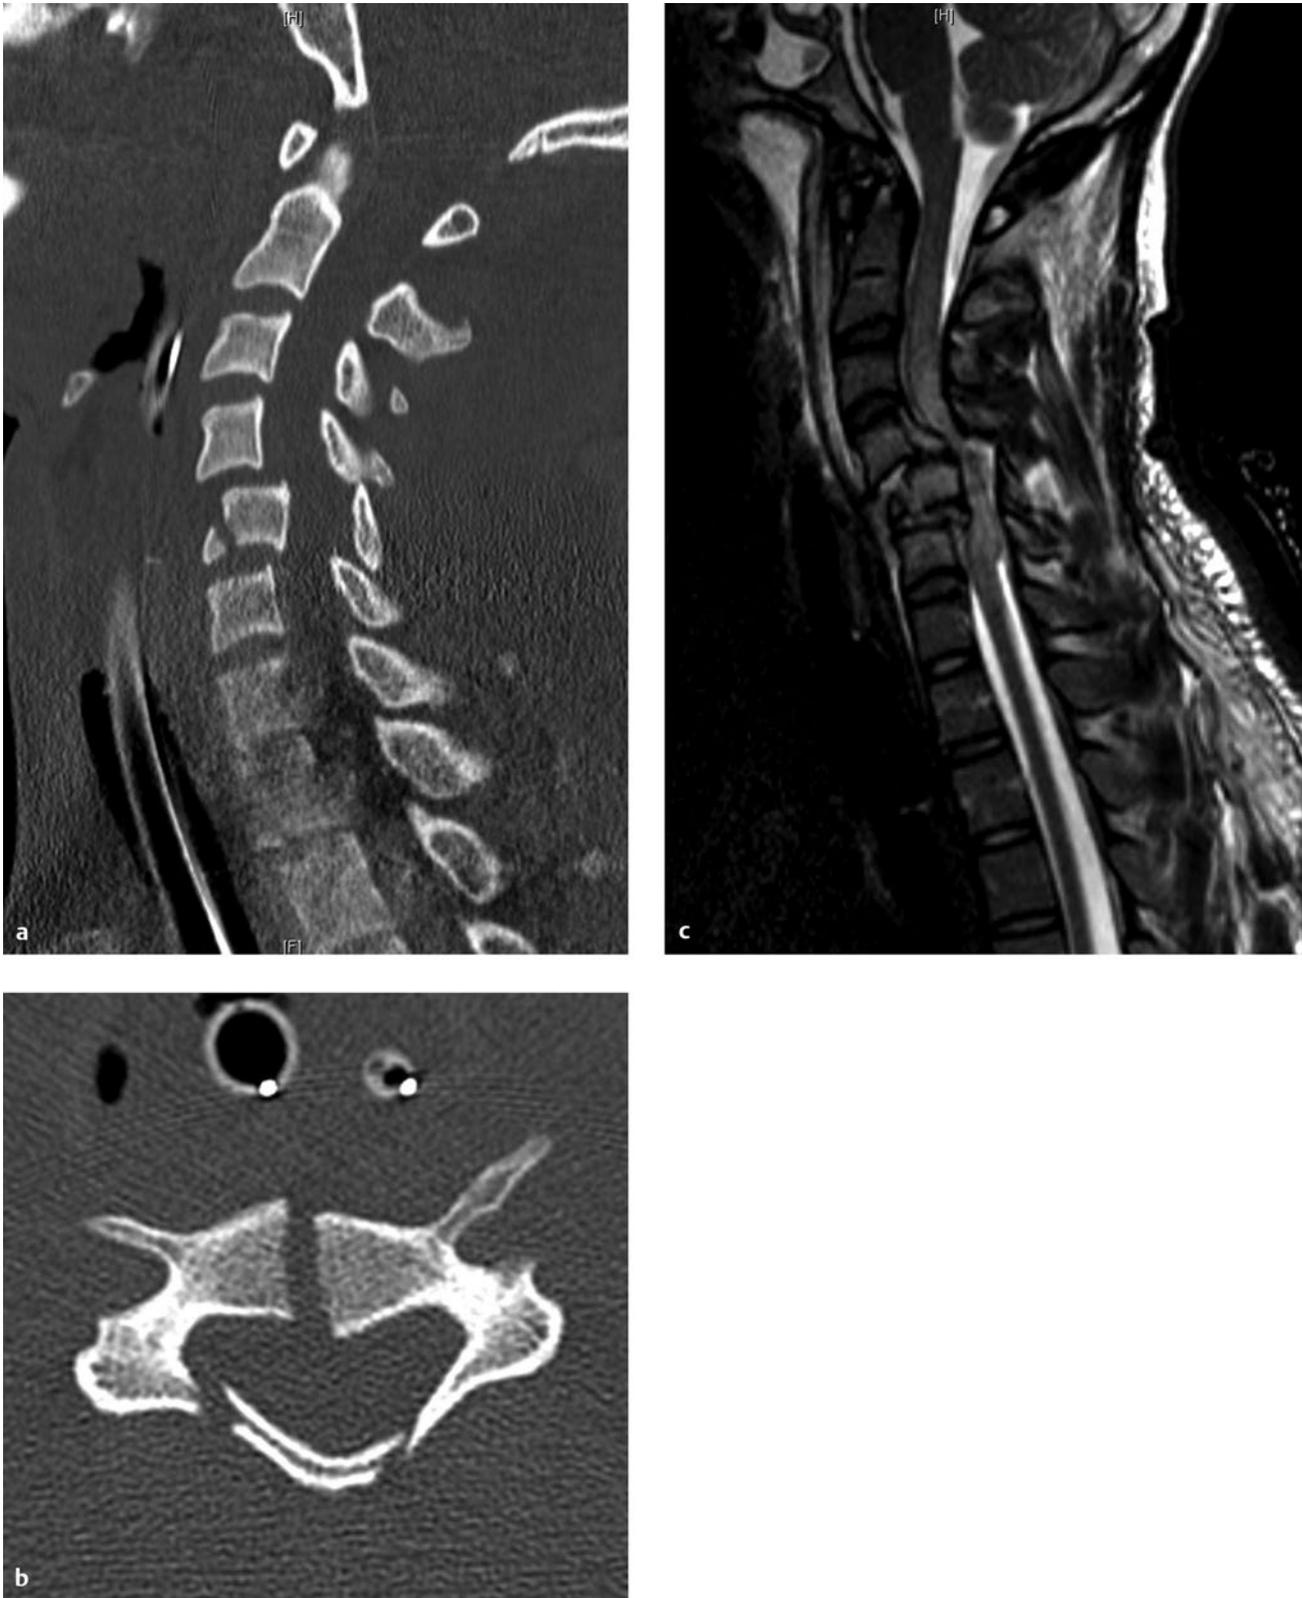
Cervical fracture–dislocation. (a,b) Sagittal and axial computed tomographic scans and (c) sagittal magnetic resonance (MR) image of an 18-year-old boy with fracture–dislocation at C5 and a complete spinal cord injury following a motor vehicle accident. This injury involves disruption of the osseous and ligamentous structures of the anterior and posterior columns of the cervical spine, resulting in gross instability. Note the displacement of the C4 vertebral body on C5 and the jumped facets at the level of injury. The MR image demonstrates disruption of the anterior and posterior longitudinal ligaments and intervertebral disks, as well as extensive soft tissue and spinal cord edema. The patient was kept in cervical traction to maintain alignment until surgical decompression and stabilization were performed.
